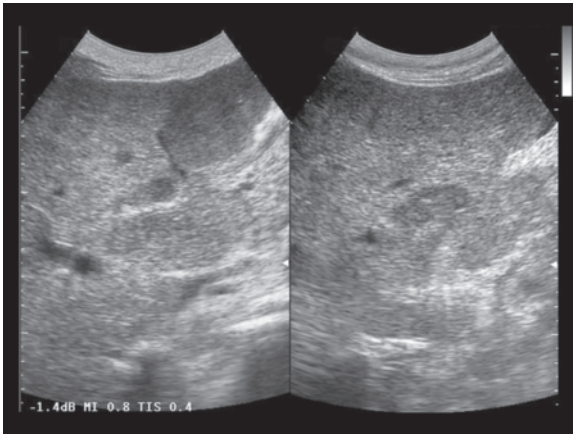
b Intrahepatic cholangiocarcinoma. Hypo-isoechoic lesion of the left hepatic lobe (a). Spectral Doppler of the left branch of the hepatic artery which is encircled by the mass (b)
